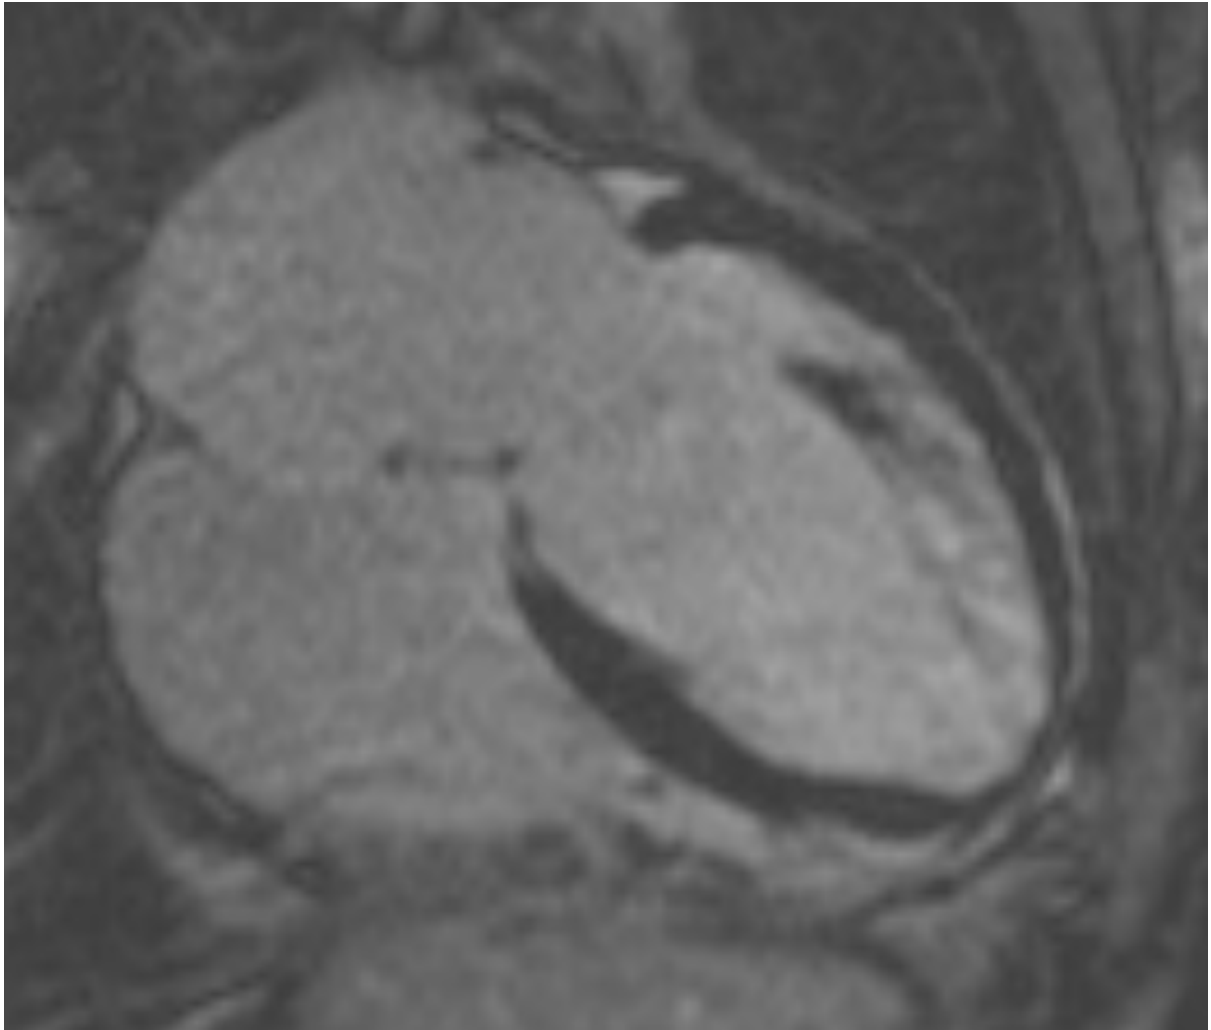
Four-chamber view on late gadolinium enhancement (LGE) cardiac MRI; showing a severely dilated left ventricle, and dilated atria. No myocardial enhancement is seen and the appearances are compatible with a dilated cardiomyopathy.
